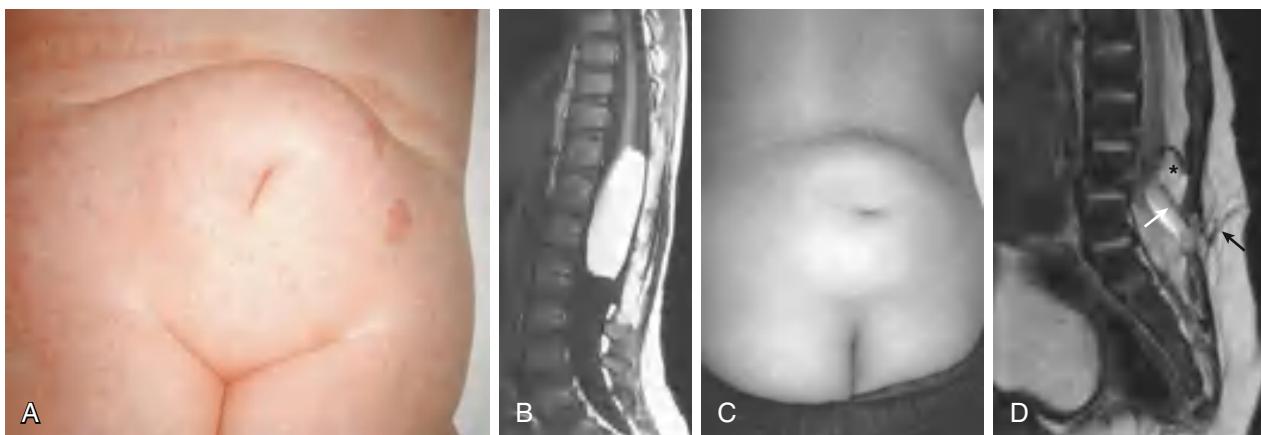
Clinical features and imaging findings associated with occult spinal dysraphism. A, Lumbosacral lipoma. The subcutaneous lipoma is in continuity with the spinal cord via a defect in the underlying muscles, bone, and dura. B, Sagittal T1-weighted image shows a huge intradural lipoma merging with the conus medullaris superiorly. C, Lipoma and central dermal sinus. D, A sagittal T2-weighted MRI of the lumbar spine demonstrates a dermal sinus (black arrow) looping underneath the lowest lamina before ascending to the low-lying conus medullaris, which it tethers. The intradural portion of the sinus tract (white arrow) is encircled by intradural lipoma (asterisk). (A from Thompson DNP. Spinal dysraphic anomalies: classification, presentation and management. *Paed Child Health*. 2014;24:431–438. Fig. 4; B from Rossi A, Biancheri R, Cama A, et al. Imaging in spine and spinal cord malformations. *Eur J Radiol*. 2004;50[2]:177–200, Fig. 9a; C, From Jaiswal AK, Garg A, Mahapatra AK. Spinal ossifying lipoma. *J Clin Neurosci*. 2005;12:714–717, Fig. 1.)
